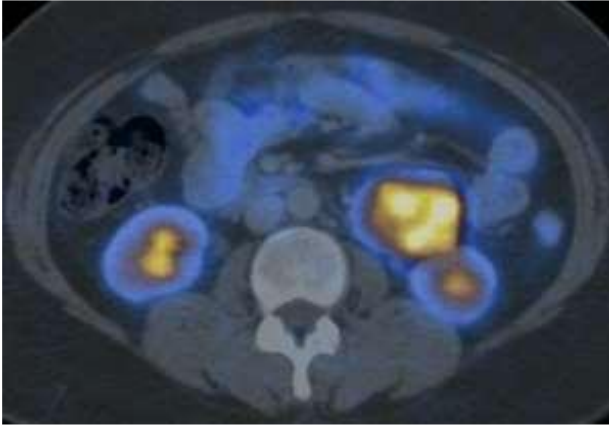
PE CT scan of patient.
